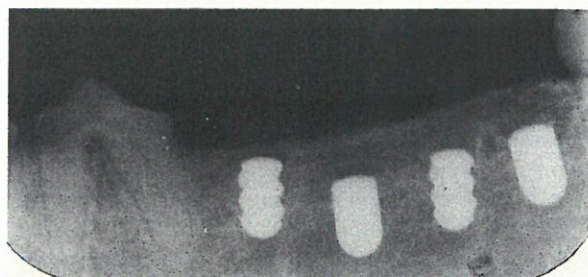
Radiograph of the same implants as in Fig 3. The radiolucencies have disappeared and the implants are well tolerated. No bone resorption is apparent; only bone apposition has taken place.
